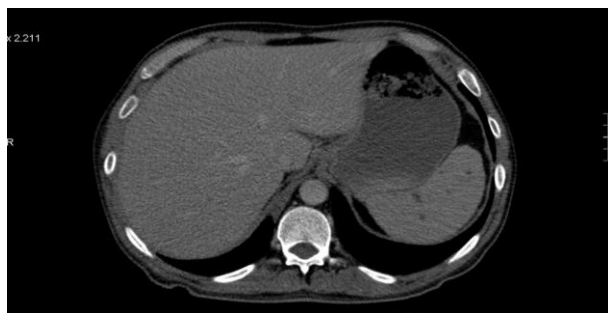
Hypodense lesions in the spleen in abdominal CT.
